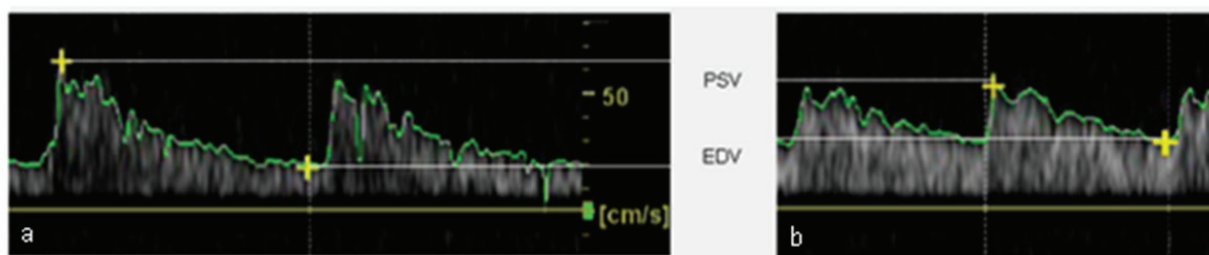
Hemodynamic parameters derived from Doppler spectrum analysis: (a) elevated PI; (b) normal PI. PSV: Peak systolic velocity; EDV: End diastolic velocity
